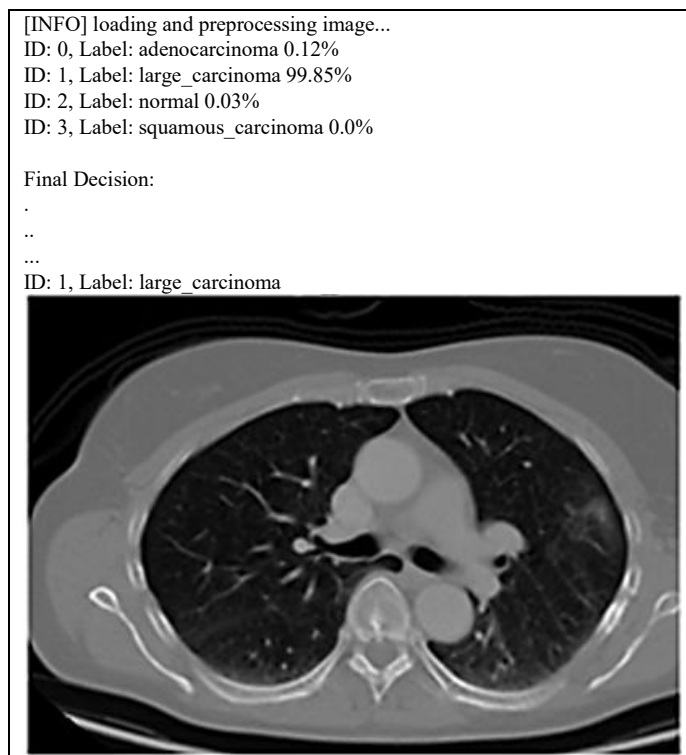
CT lung image prediction test using modified VGG16-CNN
